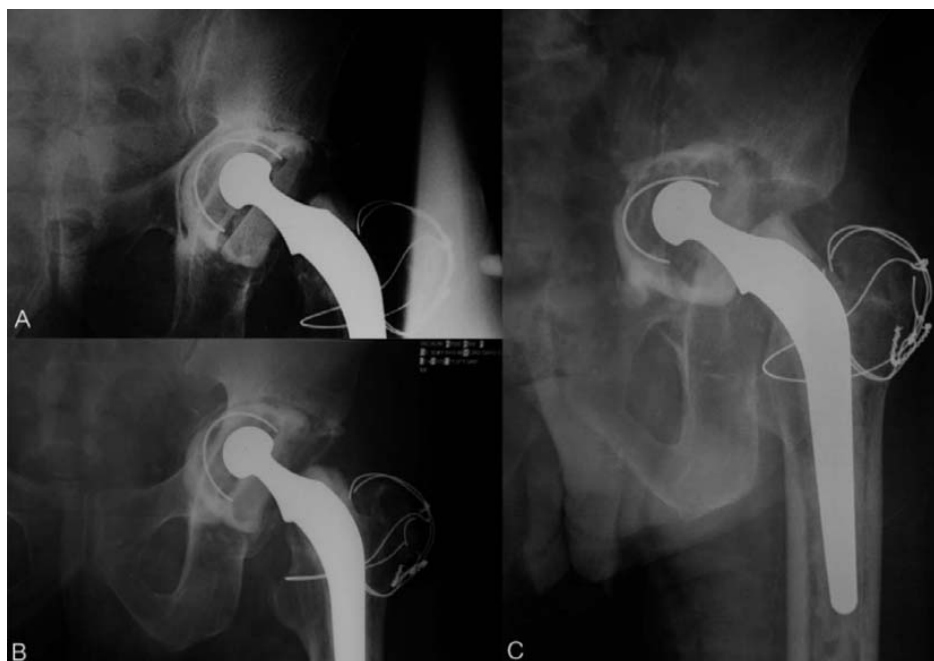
A: Radiograph at eight years after index operation demonstrates complete ≥ 2 mm radiolucency line in all zones of acetabulum. B: Radiograph at 10 years after index operation. There was a medial protrusion of both acetabular component and cemented mantle with eccentric polyethylene wear. Although the pelvic discontinuity had developed, the superior and inferior acetabular bone losses were much less severe. C: Radiograph at 11 years after index operation demonstrates extensive medial protrusion of acetabular wall into pelvic cavity with minimal superior bone-loss. When the infection has been presented for such a prolonged duration, the medial acetabular bone-loss became massive.
